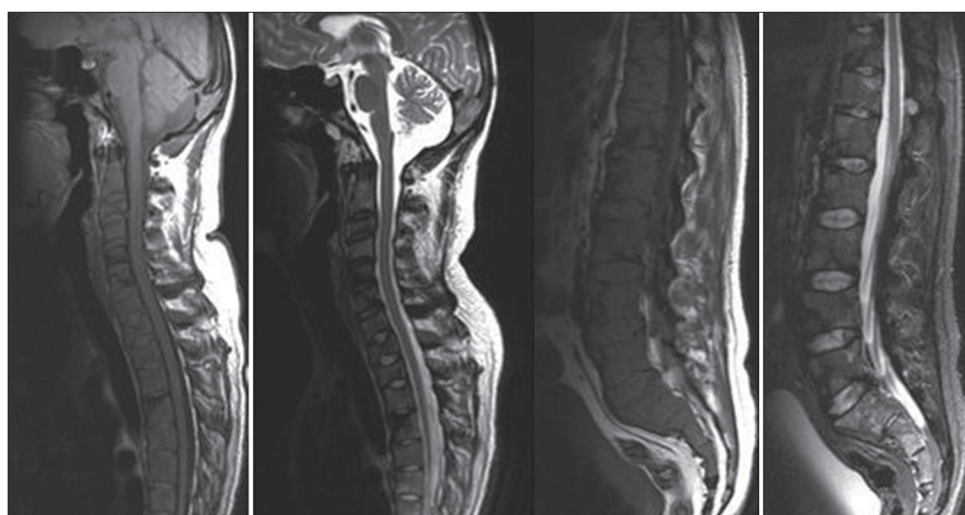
MRI spine showed extensive marrow infiltration of spine and pelvic bone and collapse of C3, D1 and D8 vertebrae in case two
